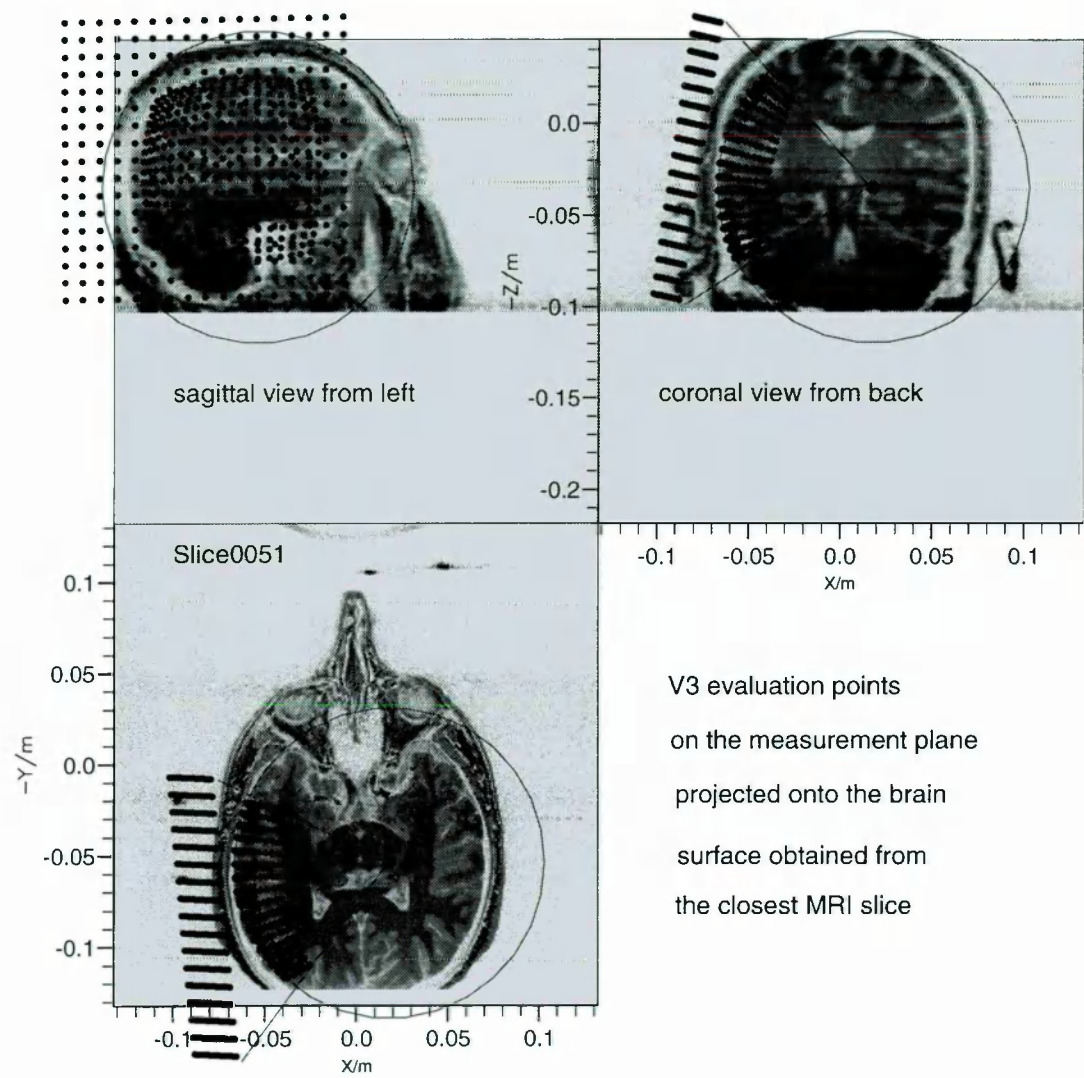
V_3 distribution projected onto the closest MRI slice: the darker dots are the 17×17 evaluation points on the measurement plane, and the lighter dots are the corresponding projected points on the brain surface. The circle stands for the hemispheric source space projected onto the closest MRI slice, and the lines show how the projection points are obtained.
